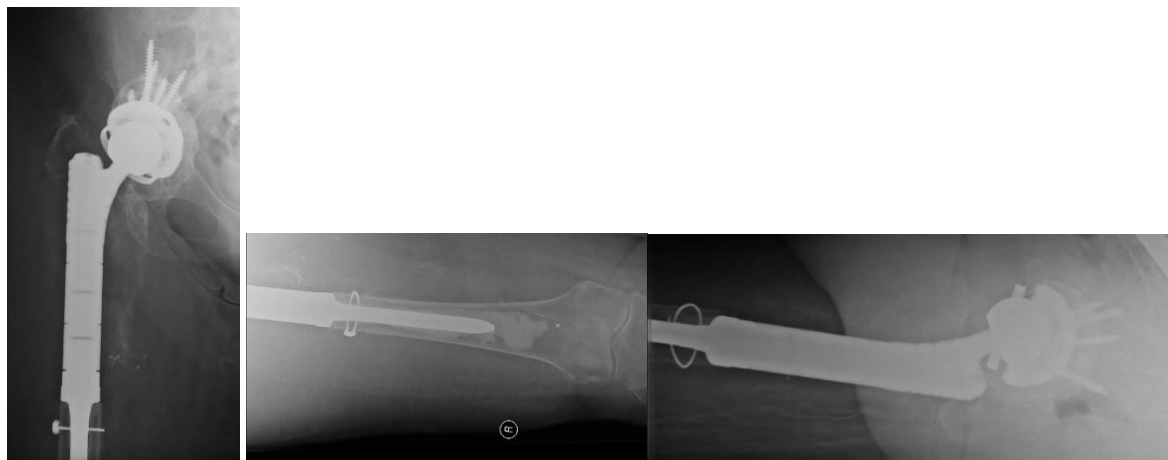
Post-operative radiographs and follow up from November 2019
